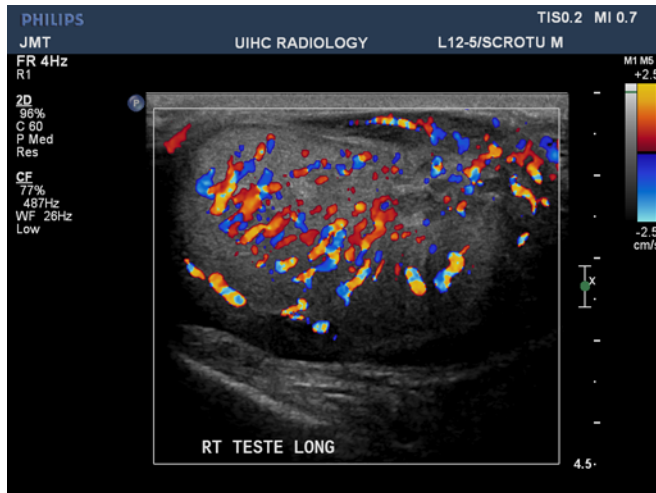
Increased vascularity on color Doppler of right testis.
